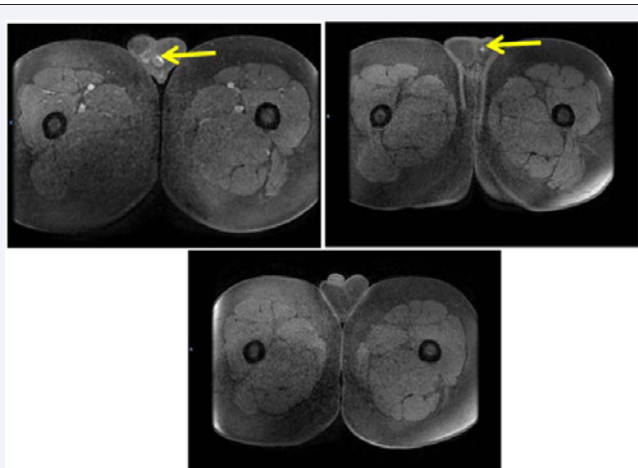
A follow-up. MR study has been obtained in 1 to 8 months. Axial and T1-weighted fat-suppressed show progressive reduction in size and signal of de lesions.
